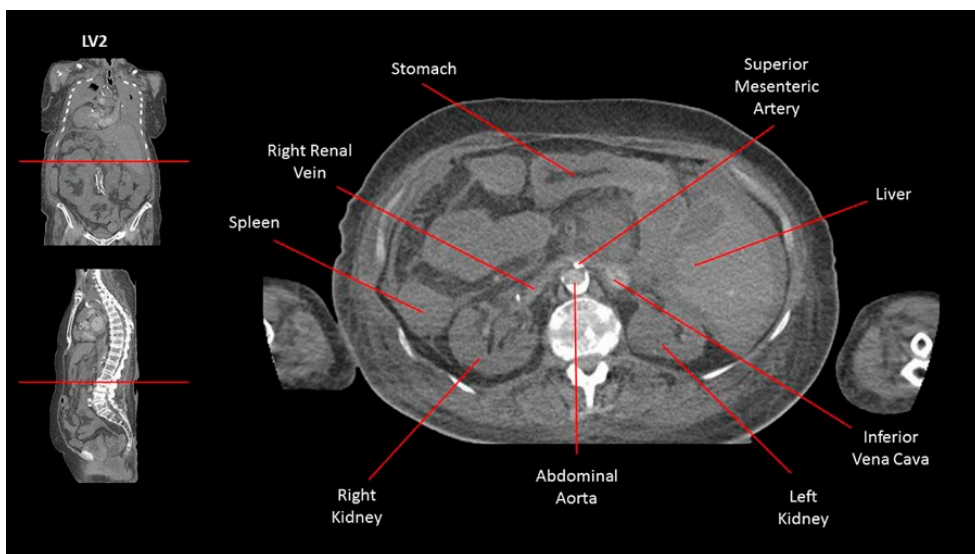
CT imaging of the right renal vein at the lumbar vertebral level 2 (LV2). The right renal vein passes anterior to the abdominal aorta and posterior to the superior mesenteric artery before draining into the inferior vena cava on the left side of the abdomen. The red lines in the coronal and sagittal images denote the vertebral level.
